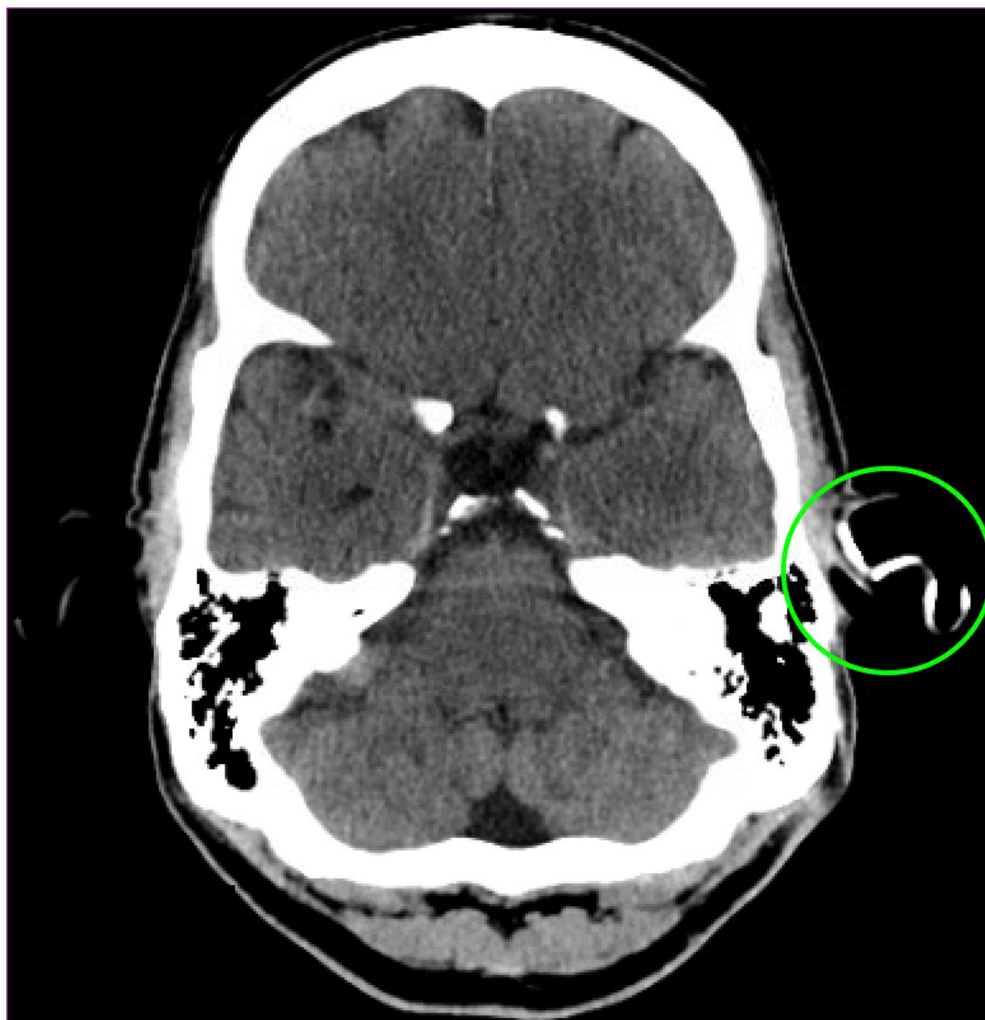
CT scan demonstrating calcification of the left auricular and external ear canal cartilage
